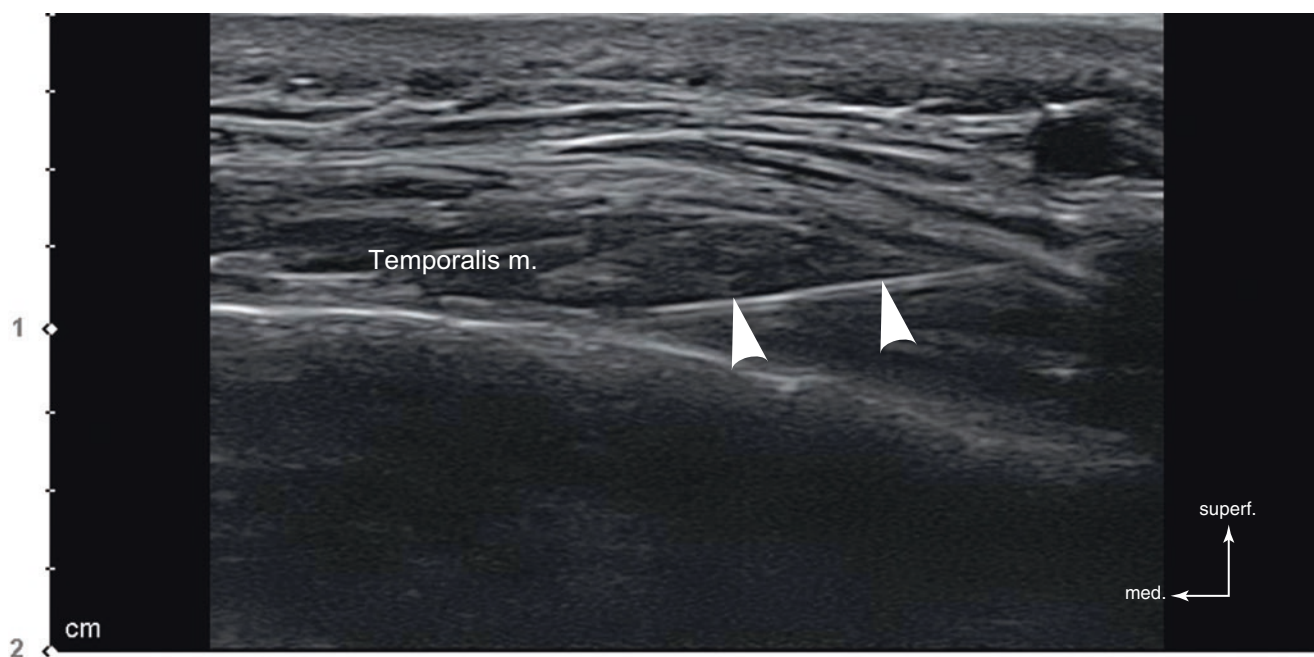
Ultrasonography-guided botulinum toxin injection to the temporalis muscle (in-plane), B mode (transverse view, 15 MHz by linear transducer) (white arrowheads: injection needle). (Published with kind permission of © Ji-Soo Kim 2020. All Rights Reserved)
